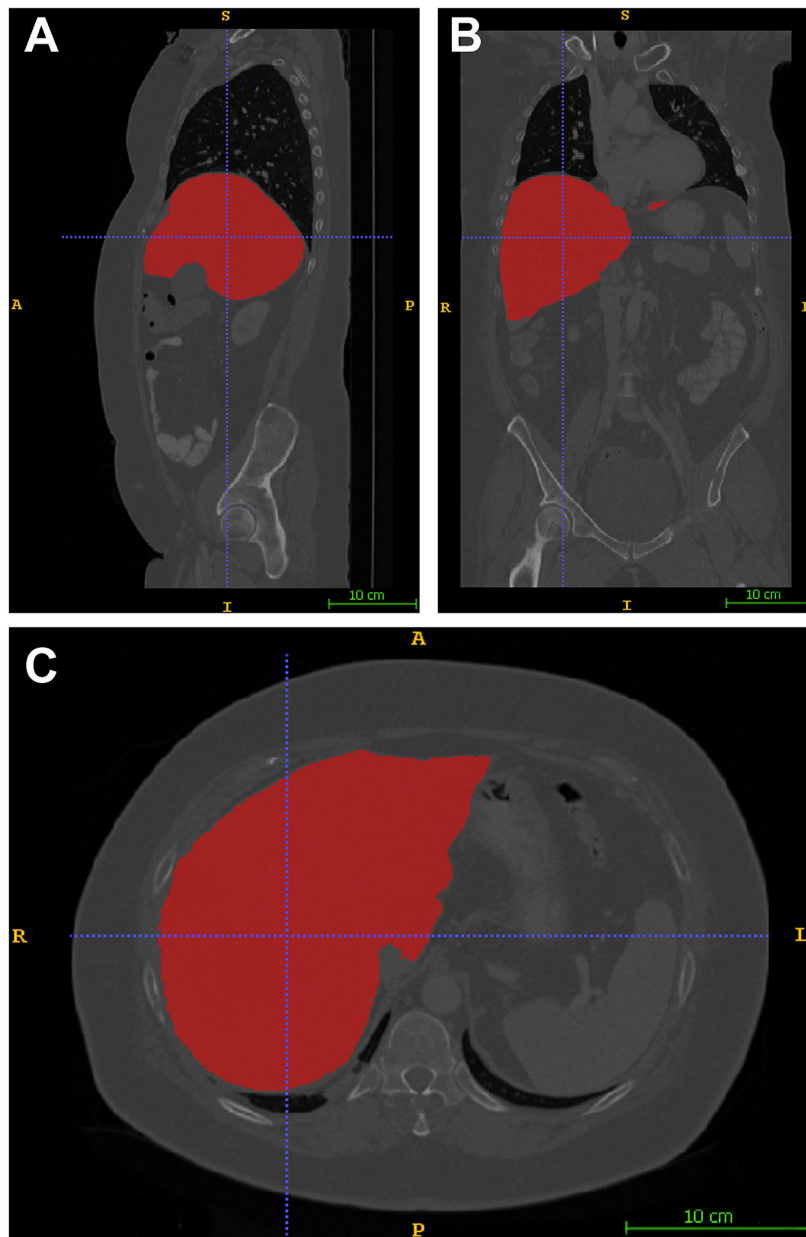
nnU-Net segmentation and color annotation of liver parenchyma superimposed onto original computed tomography image. Areas identified by nnU-Net as part of the liver are noted in red in sagittal cross-section (A), coronal cross-section (B), and transverse cross-section (C).
